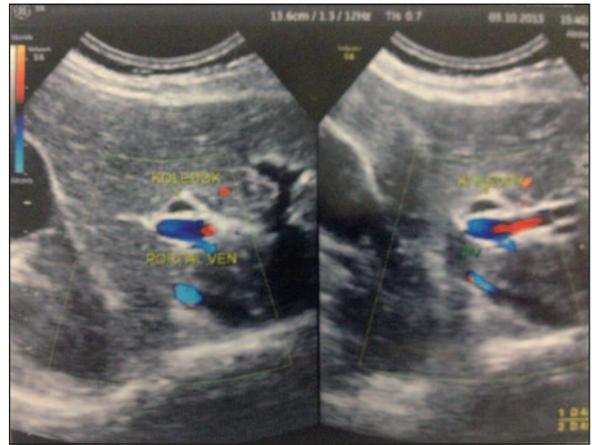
In ultrasonographic examination, there was no gallbladder in place; intrahepatic bile ducts and choledochus were normal.
